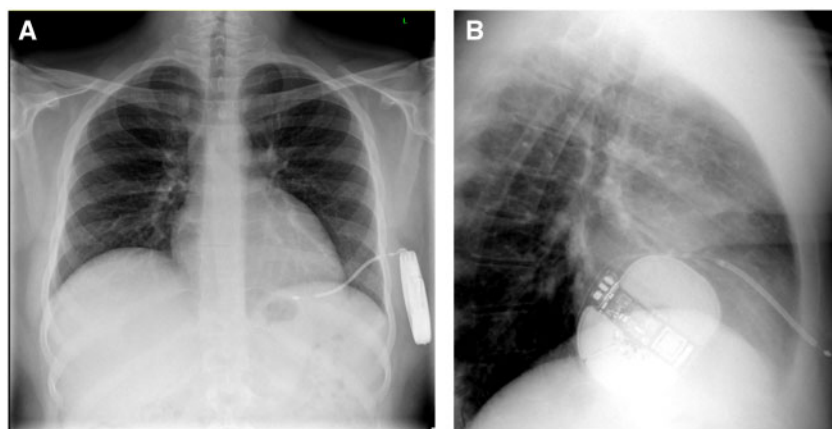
Chest radiograph after an inappropriate shock showing retraction of the chest lead back towards the subcutaneous implantable cardioverter-defibrillator generator. (A) PA projection. (B) Lateral projection.
